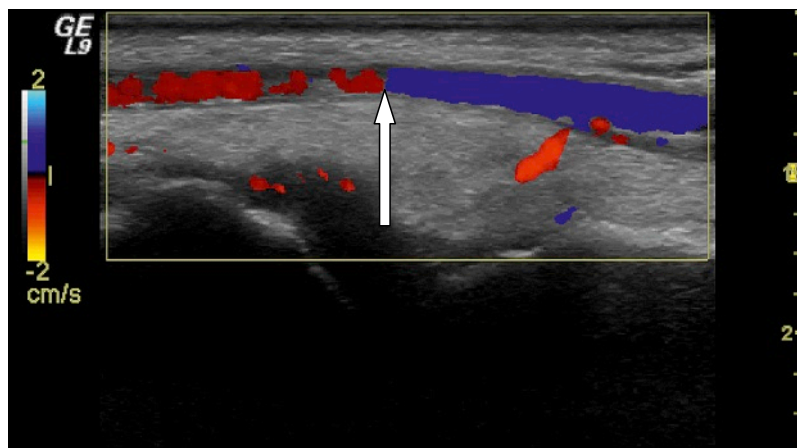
TRUE REVERSE FLOW. The *blue* color indicates flow toward the transducer and the *red* color shows flow away from the transducer. Between the opposite directions of flow there is a detectable *black line* (*white arrow*), because between the areas with opposite directions, there must be an area with no velocity because the blood runs parallel to the transducer and no Doppler shift is detected (insonation angle of 90 degrees) and therefore no signal is produced.
